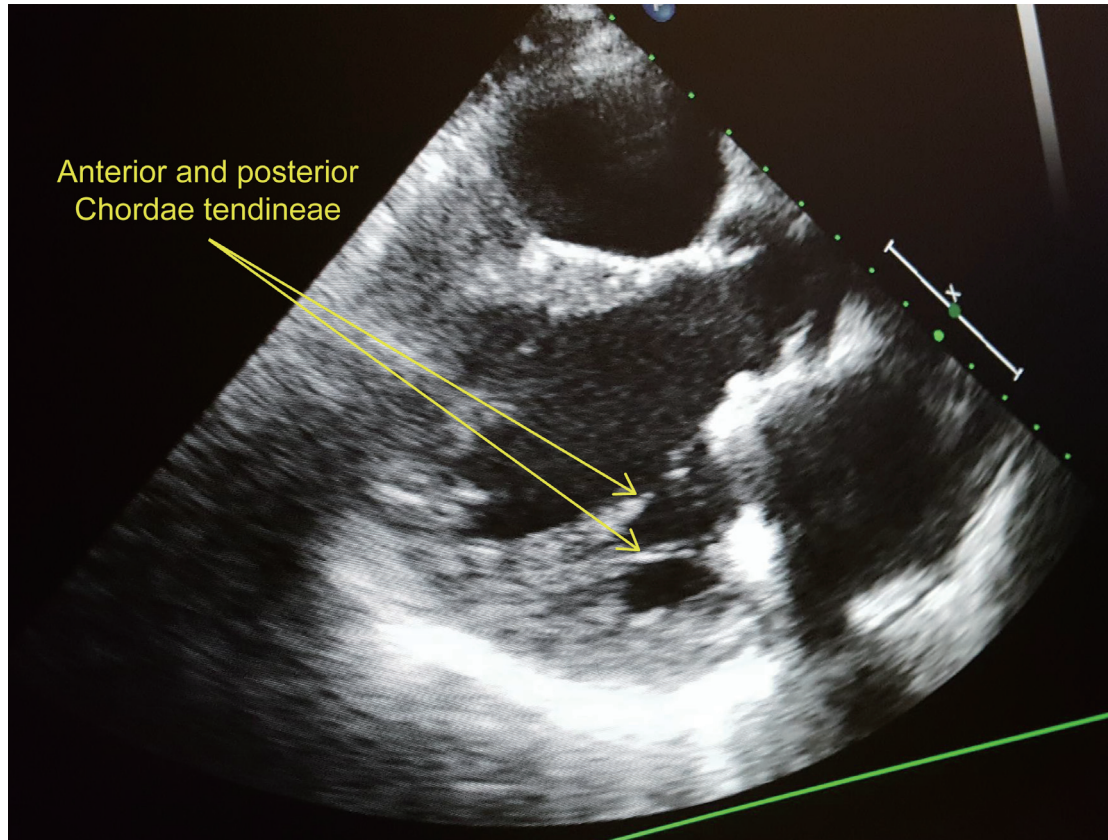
Postoperative echocardiography. Preservation of the entire subvalvular apparatus did not interfere with the left ventricular outflow tract.
